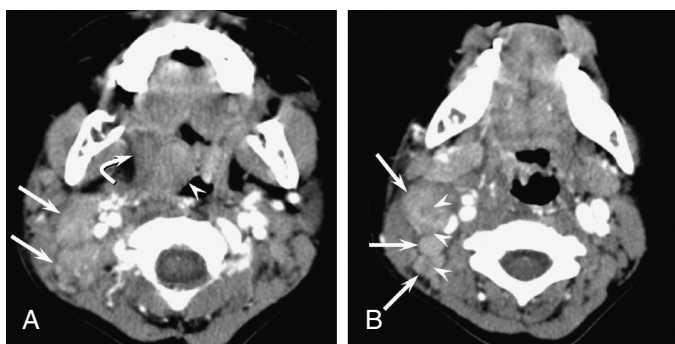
Contrast-enhanced CT in 3-yr-old boy with Kawasaki disease. A, Right-sided cervical lymphadenopathy (arrows), peritonsillar hypodense area (curved arrow), and swelling of right palatine tonsil (arrowhead). B, Right-sided cervical lymphadenopathy with perinodal infiltration (arrows) and intranodal focal low attenuation (arrowheads). (From Kato H, Kanematsu M, Kato Z, et al. Computed tomographic findings of Kawasaki disease with cervical lymphadenopathy. *J Comput Assist Tomogr*. 2012;36[1]:138–142, Fig. 1, p. 139.)
